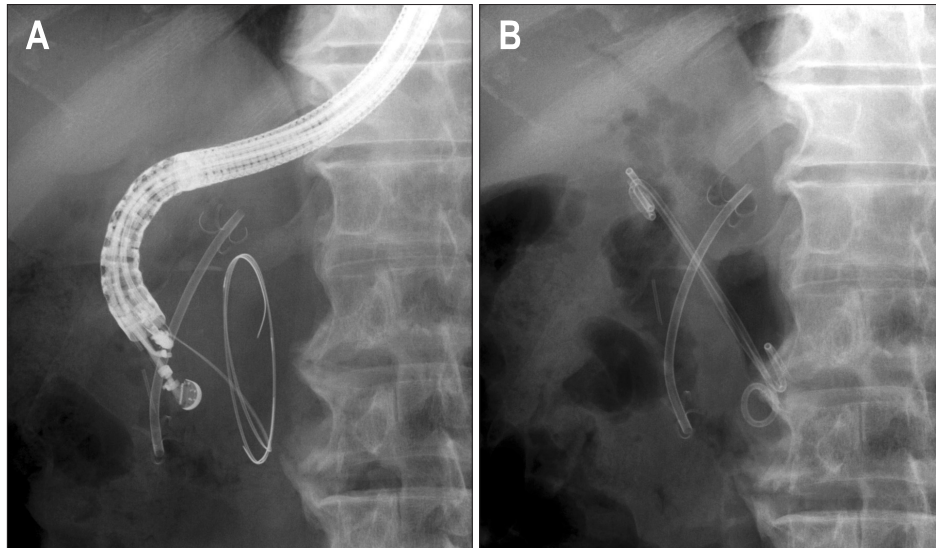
(A) Radiograph showing a double guidewire in the pancreatic pseudocyst. (B) After double guidewire placement, a double pigtail plastic stent was advanced into the pancreatic pseudocyst.
